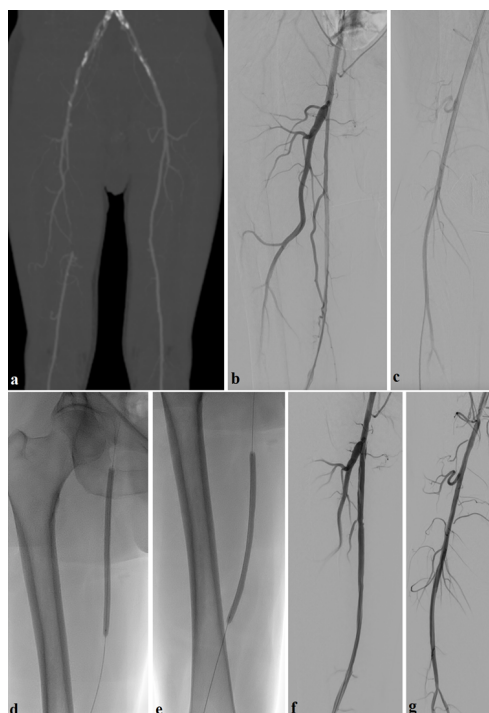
(a) CT angiography showing extensive calcifications in the bilateral iliac arteries, with an occlusion in the right superficial femoral artery. The bilateral common femoral arteries (CFA), left superficial femoral artery, and both popliteal arteries remained patent. (b, c) Following retrograde access through the right anterior tibial artery at the ankle level, a diagnostic catheter and guidewire were advanced to the right external iliac artery. Digital subtraction angiography images revealed areas of steno-occlusions within the superficial femoral artery. (d, e) Balloon angioplasty was carried out at the sites of steno-occlusions in the superficial femoral artery. (f, g) Final Digital subtraction angiography images post-balloon angioplasty indicating full patency of superficial femoral artery.
